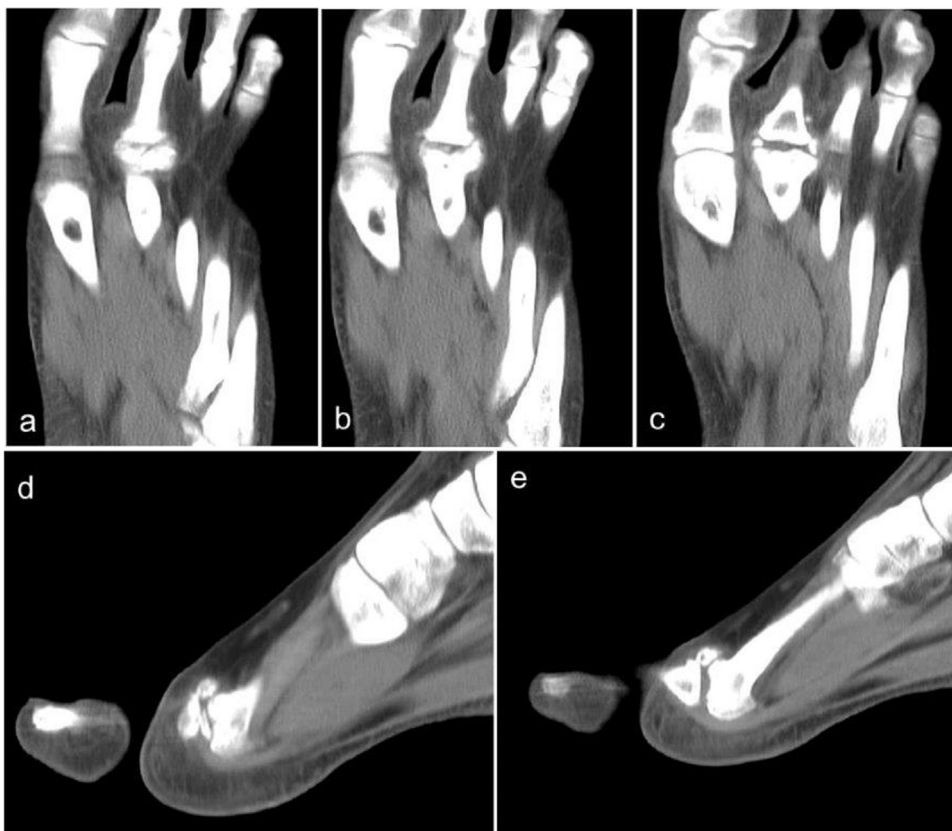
a–c) antero-posterior CT images of the left foot showing the fragmentation and flattening of the second metatarsal head; d, e) Sagittal CT images showing flattening and fragmentation of the second metatarsal head, in particular in its superior part, confirming the diagnosis.
